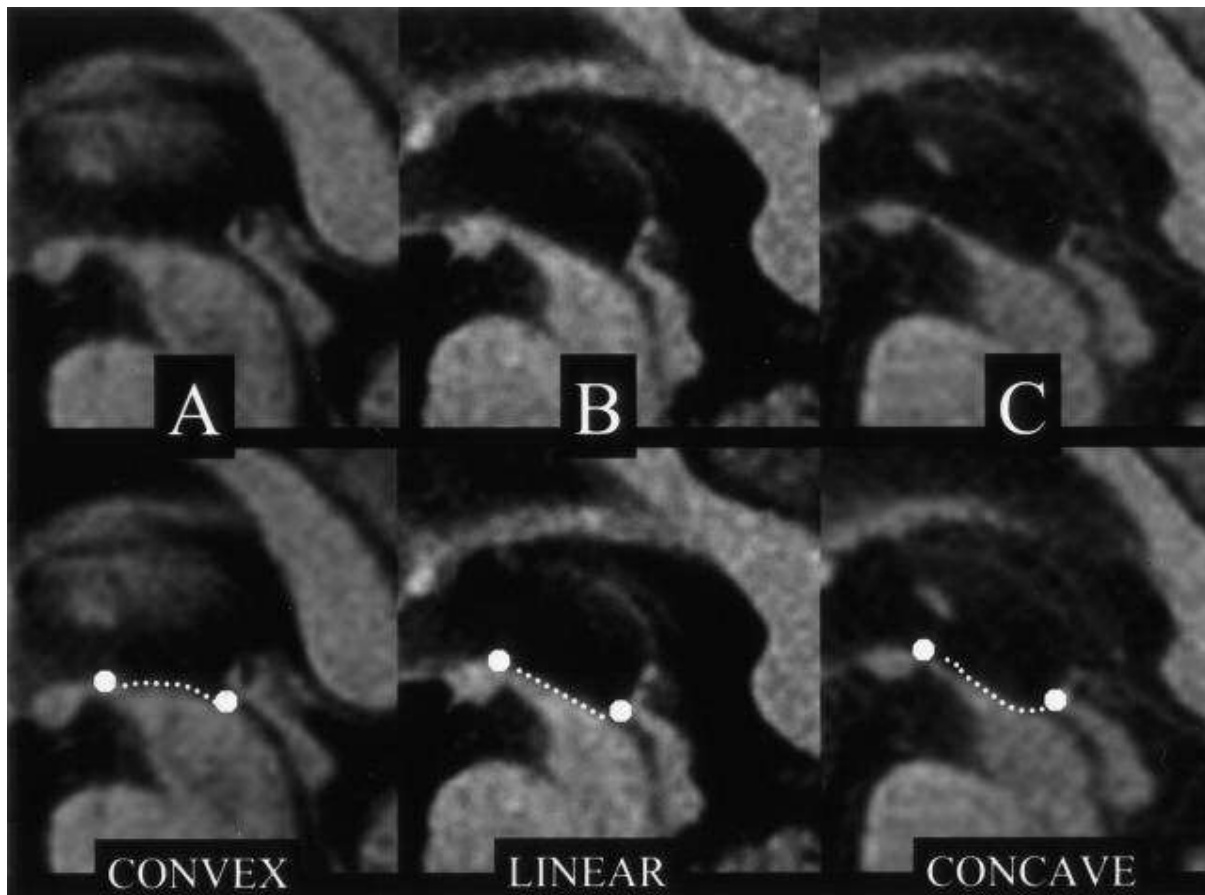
Top row, Midsagittal T1-weighted spin-echo sections in PD (A) and PSP (B and C) show the midbrain region. Bottom row, the same images with outlined profiles of the upper midbrain, appears convex in A, linear (flat) in B and concave in C.
